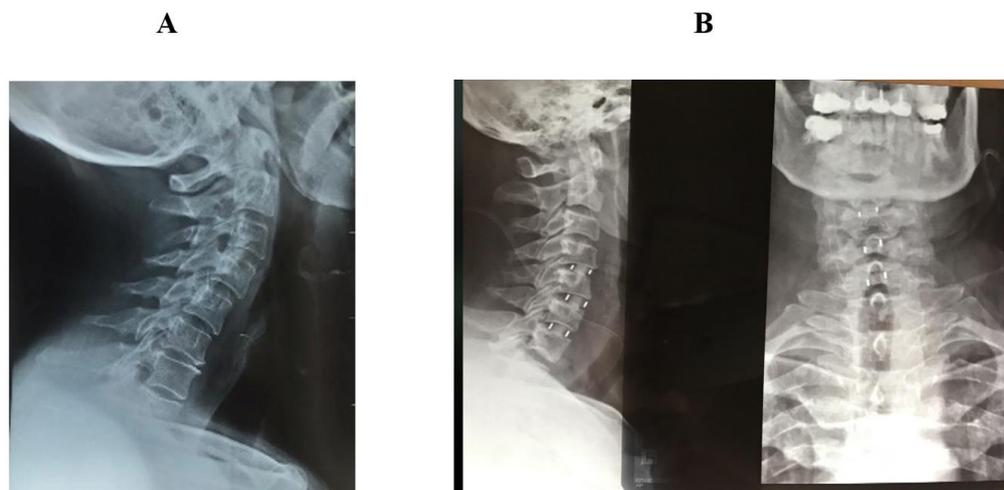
A: Preoperative lateral cervical radiography with kyphotic deformity. B: Postoperative lateral and AP radiography with cages at Cervical 4-5, Cervical 5-6, Cervical 6-7, and correction of deformity of kyphosis.
